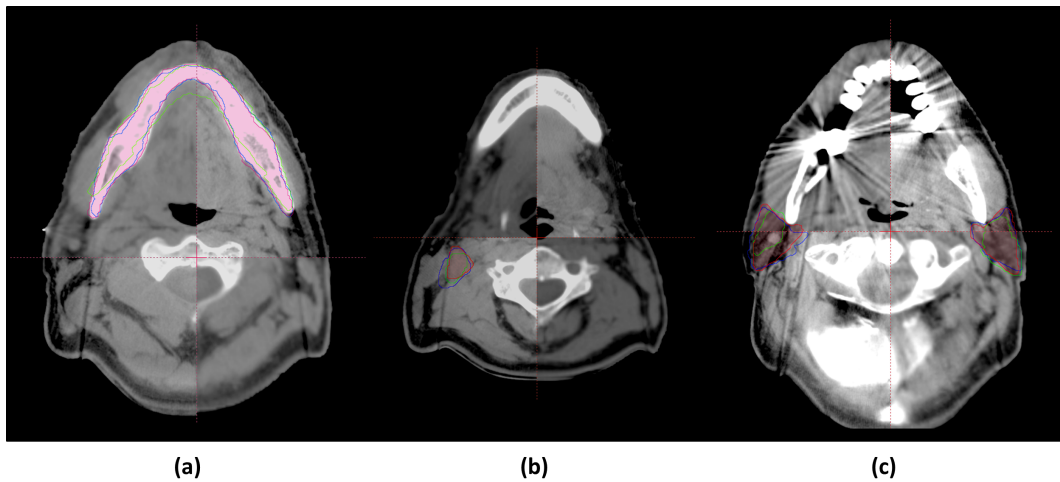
Checkerboard rendering of three axial slices of patient 19a, comparing *virtualCT* and CBCT scans. Manually outlined (red) and automatic (blue) mandible, nGTV and parotids are presented in panels (a), (b) and (c) respectively. In green, we report the contour that would have been obtained by rigid registration of CTsim on CBCT. nGTV contour highlights the variability of the obtained results.
